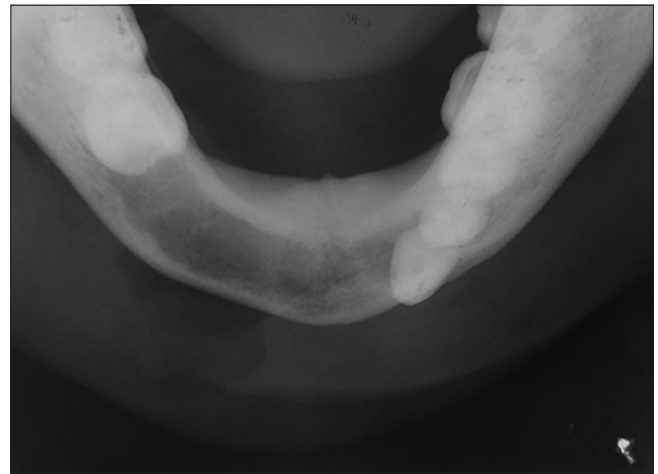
Case 2 - Mandibular occlusal radiograph showing oro-cutaneous fistula
